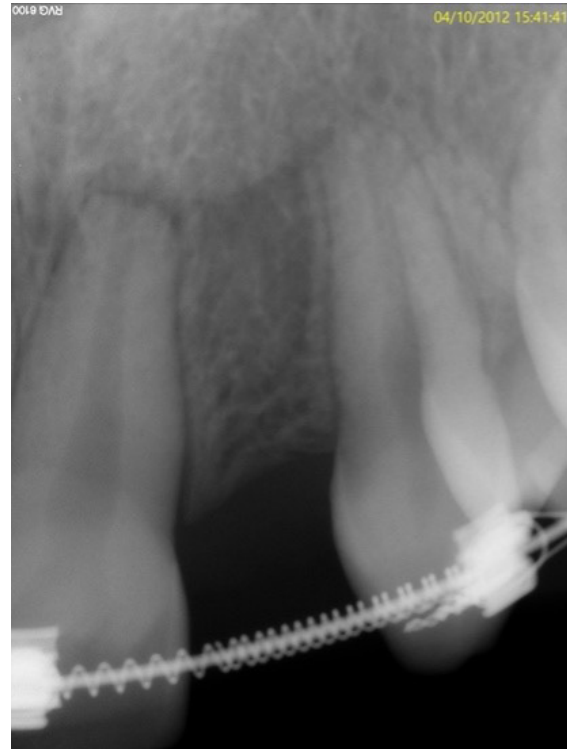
Periapical Rx of the left side
